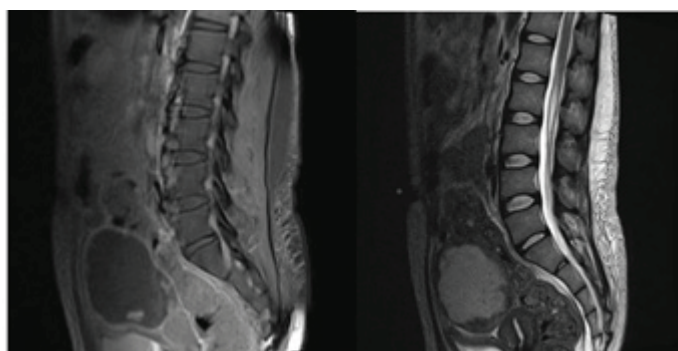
pre-operative pelvic images: MRI identified an abdominal mass repressing pelvic organs suspect of a pelvic abscess
